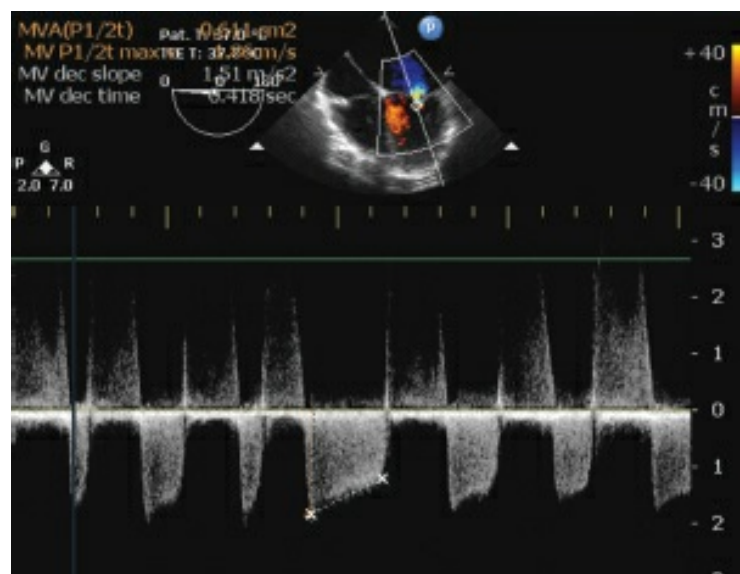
Continuous wave Doppler across the stenosed mitral valve showing increased velocity and the deceleration time. The pressure half-time method to calculate the mitral valve area can be used with this trace.
